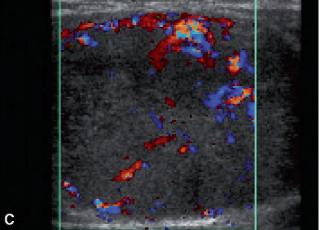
Ultrasound of follicular adenoma in the right lobe. A, Transverse, 31 x 32 mm. B, Longitudinal, sagittal diameter: 40 mm. C, Color Doppler.
